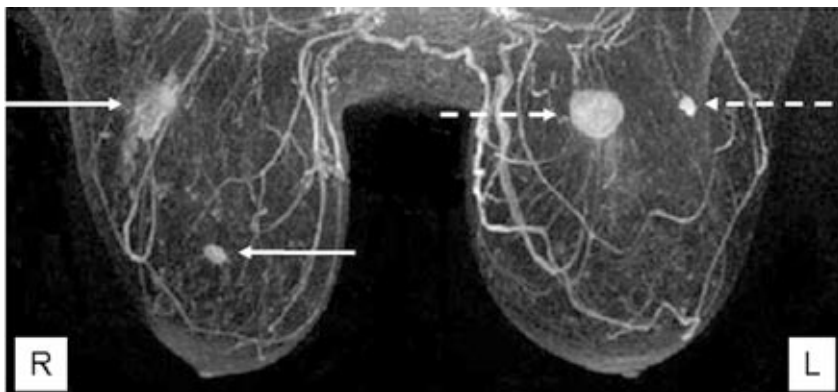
Subtraction maximum intensity projection in three dimensions of dynamic enhanced magnetic resonance image showing two tumour foci in the right breast (R; solid arrows) and left breast (L; broken arrows). The normal breast vasculature is also clearly seen
